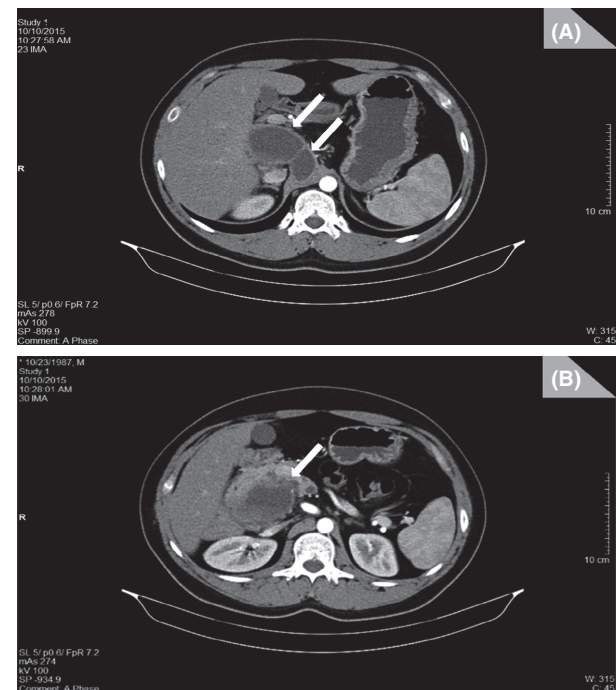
(CT scan): (A and B) The multiloculated cystic retroperitoneal lesion (white arrows), at the level of the second portion of the duodenum in continuity with the pancreatic head which is displaced anteriorly and to the right.
